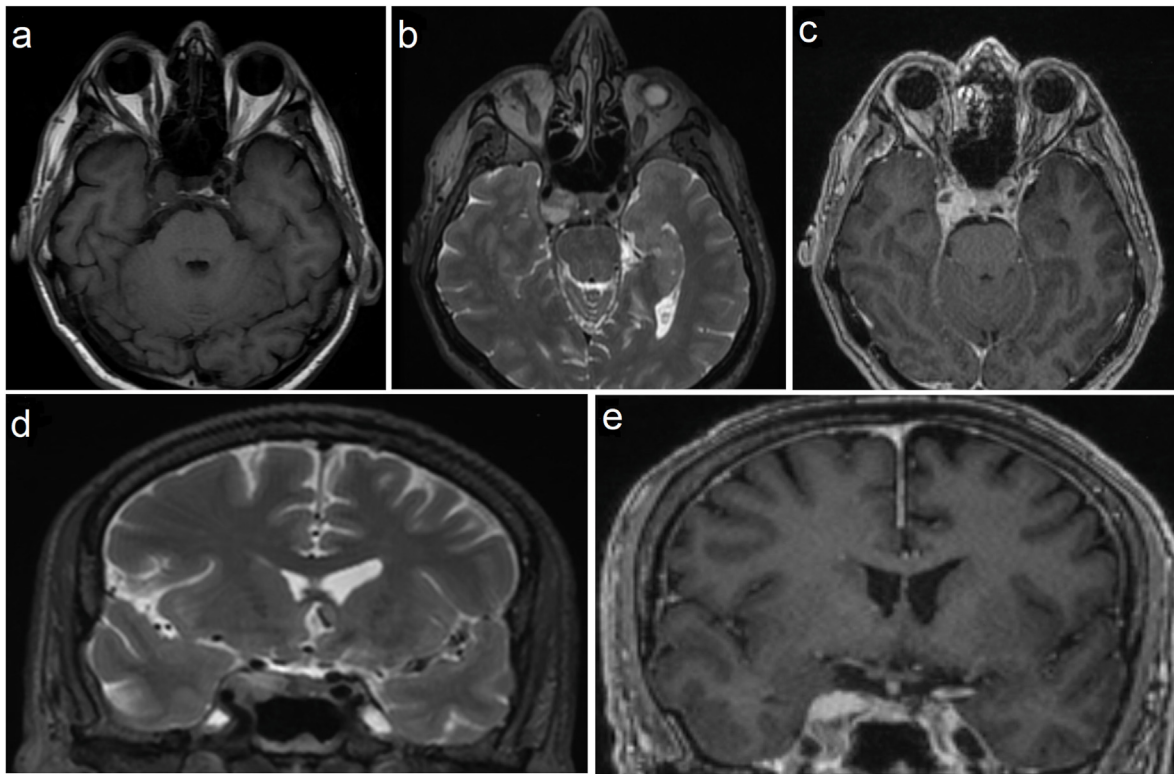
On magnetic resonance imaging, capillary hemangioma is hypointense on T1 sequence axial section (a) and hyperintense on T2 sequence axial (b) and coronal section (d). Capillary hemangioma appearing homogeneously enhanced on axial (c) and coronal (e) sections on Gadolinium enhanced T1 sequence images.
